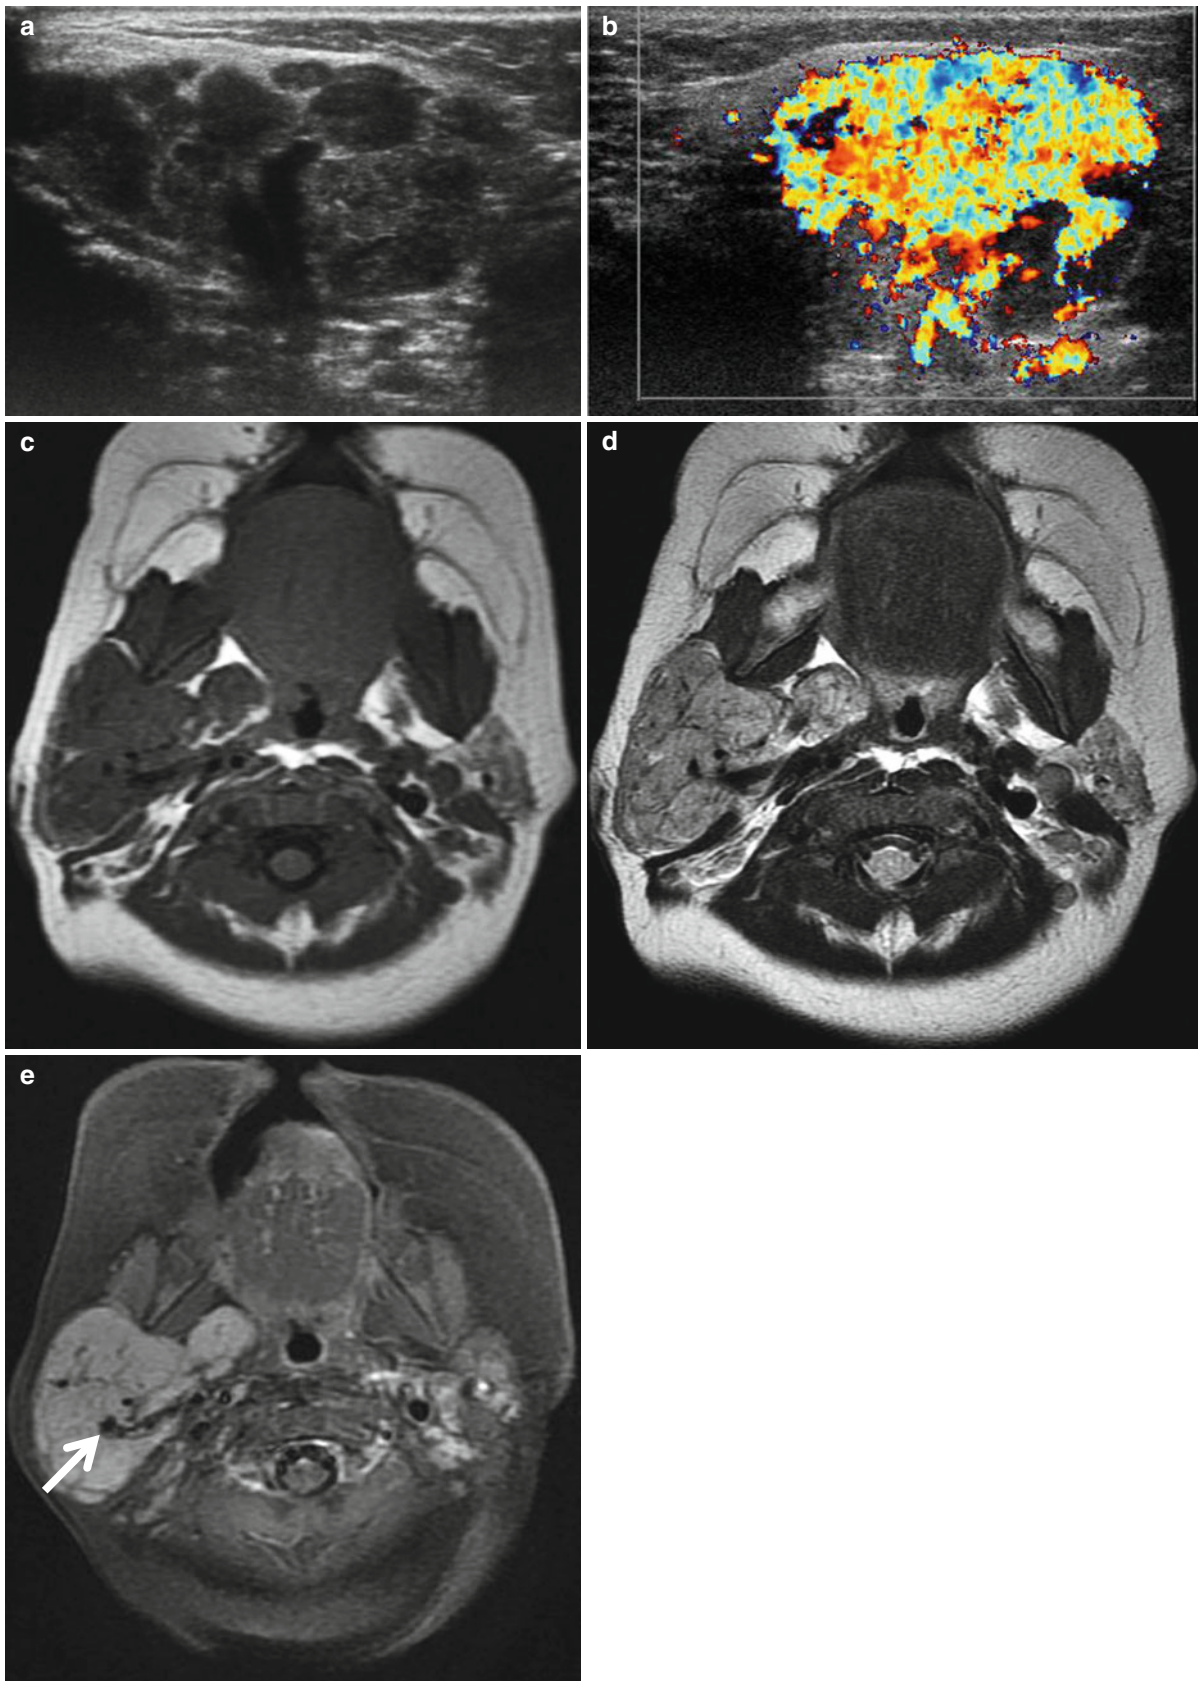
Parotid hemangioma in a 4-month-old girl. (a, b) Gray and color Doppler US scans show a lobulating, heterogeneous solid mass with extensive hypervascularity in the right parotid gland. (c) Axial T1-weighted MR image shows a homogeneous iso-signal intensity of the mass relative to the muscle involving the entire right parotid gland.
